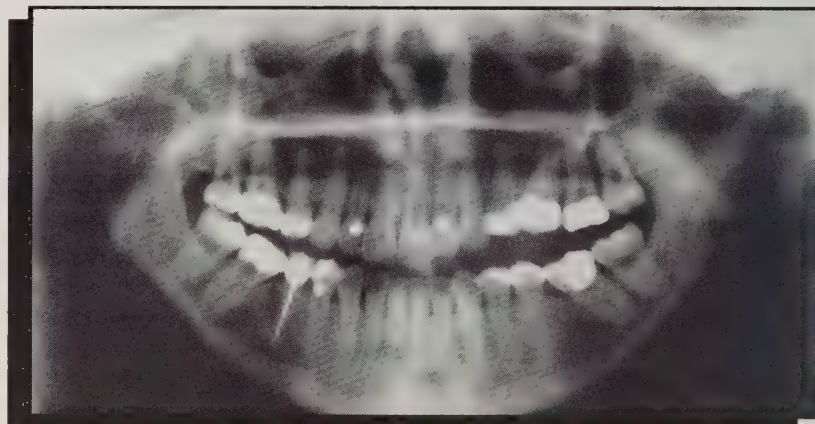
Panoramic radiograph taken one year after Fig. 13, showing progression of proximal segment degeneration.
